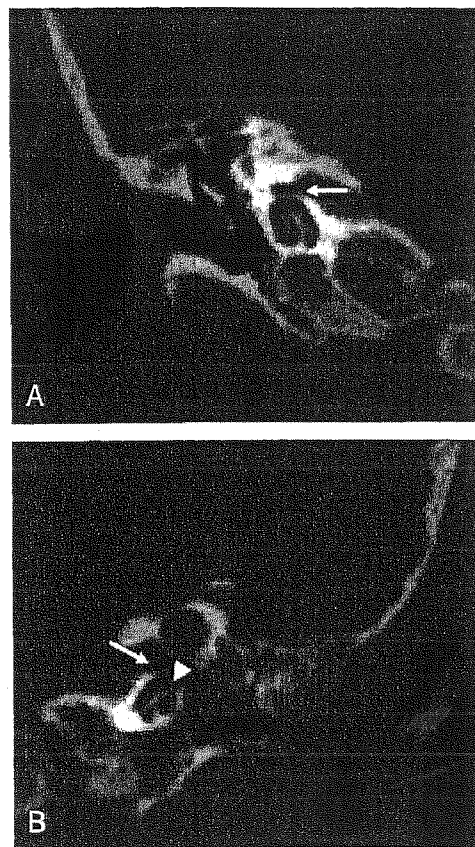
Preoperative coronal CT scan, without contrast. A, Right ear: normal, movement artefact. B, Left ear: broadening of the labyrinthine portion of the facial canal (*white arrow*) and cochlear destruction (*white arrowhead*).
